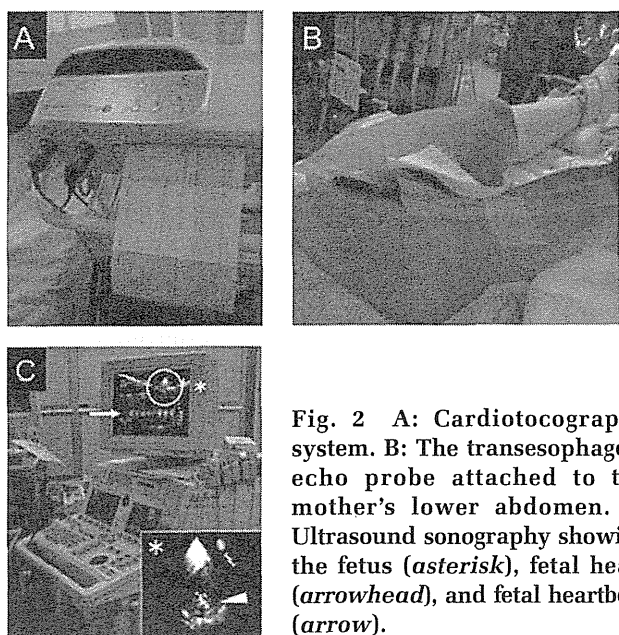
A: Cardiotocography system. B: The transesophageal echo probe attached to the mother's lower abdomen. C: Ultrasound sonography showing the fetus (asterisk), fetal heart (arrowhead), and fetal heartbeat (arrow).
